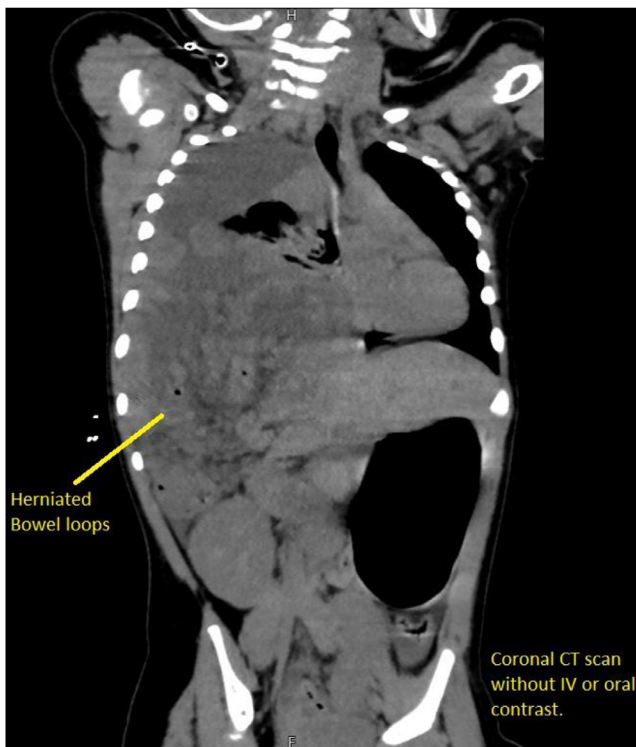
Coronal CT shows herniated bowel loops.
